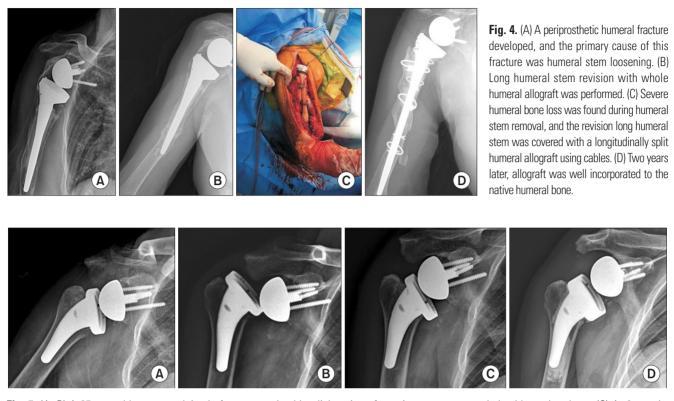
(A, B) A 65-year-old man complained of recurrent shoulder dislocation after primary reverse total shoulder arthroplasty. (C) At 6 months postoperative, X-ray showed humeral stem loosening around the humeral metaphysis. (D) Revision surgery was performed using an augmented metaphysis and cemented stem.
